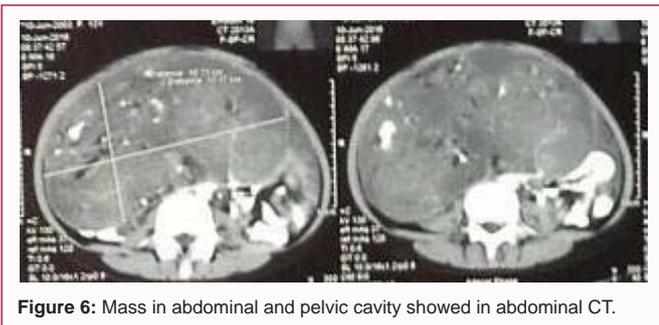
Mass in abdominal and pelvic cavity showed in abdominal CT.
